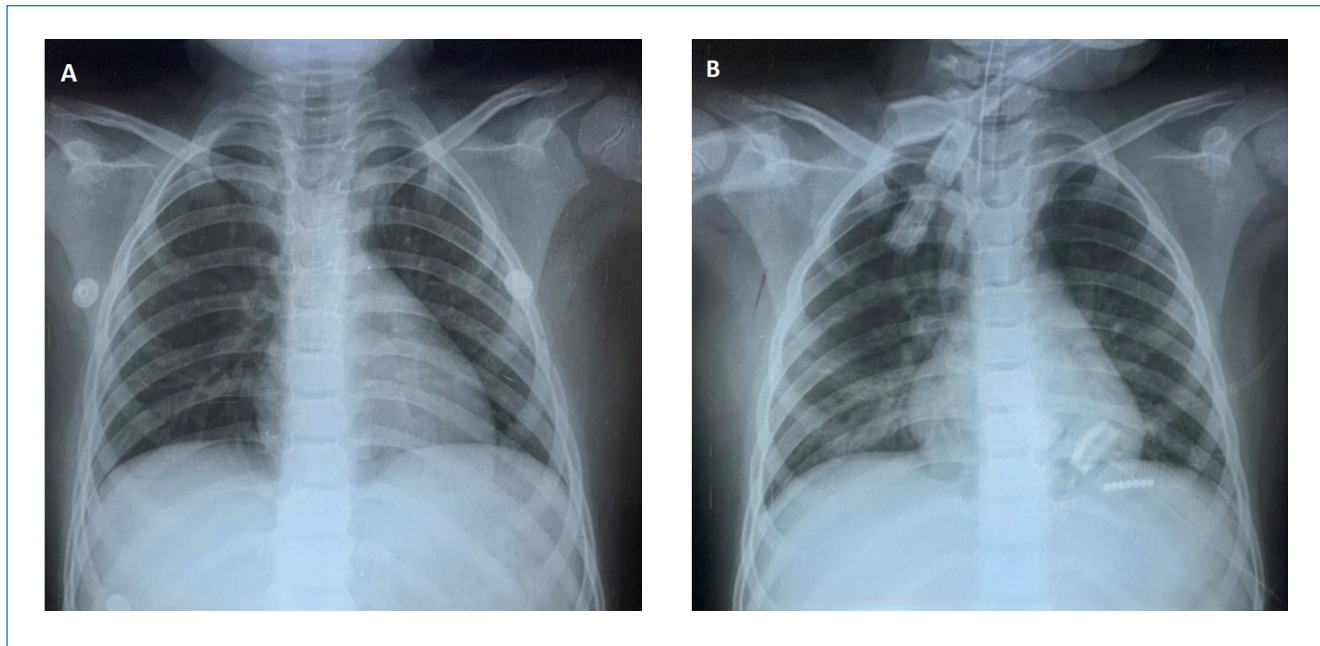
Chest radiographs. No radiological findings of pneumonia were present in the Day 0 (A) and Day 1 (B) of admission.
